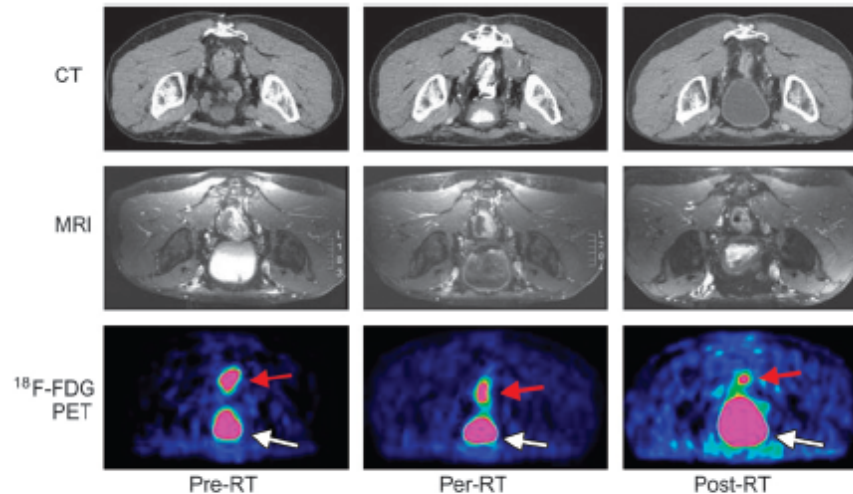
Imaging studies performed before and during course of treatment for patient with rectal cancer. (Upper row) Images from CT performed in prone position before chemoradiotherapy (RT), during chemoradiotherapy, and at time of surgery. (Middle row) Images from MRI performed in supine position before chemoradiotherapy, during chemoradiotherapy, and at time of surgery. (Lower row) Images from ¹⁸F-FDG PET performed before chemoradiotherapy, during chemoradiotherapy, and at time of surgery. Tumor (red arrows) shows high level of uptake of ¹⁸F-FDG before start of treatment; ¹⁸F-FDG signal decreases during treatment and is lowest at time of surgery. ¹⁸F-FDG PET can help in delineating GTV before treatment and in replanning radiation treatment during course of treatment. White arrows indicate urinary bladder.
